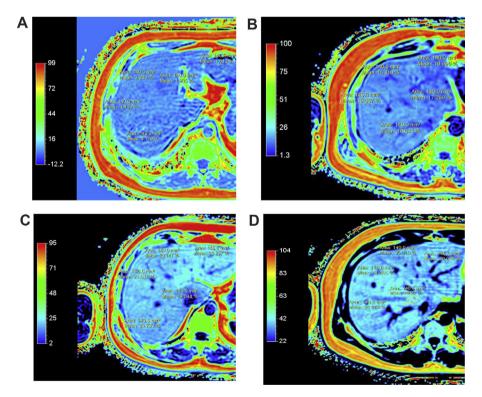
(A) MRI-PDFF showing normal liver (PDFF value < 6.5%). (B) MRI-PDFF showing Grade I fatty liver (PDFF value > 6.5 and < 17.4%). (C) MRI-PDFF showing Grade II fatty liver (PDFF value > 17.4 and < 22.1%). (D) MRI-PDFF showing Grade III fatty liver (PDFF value > 22.1%).
